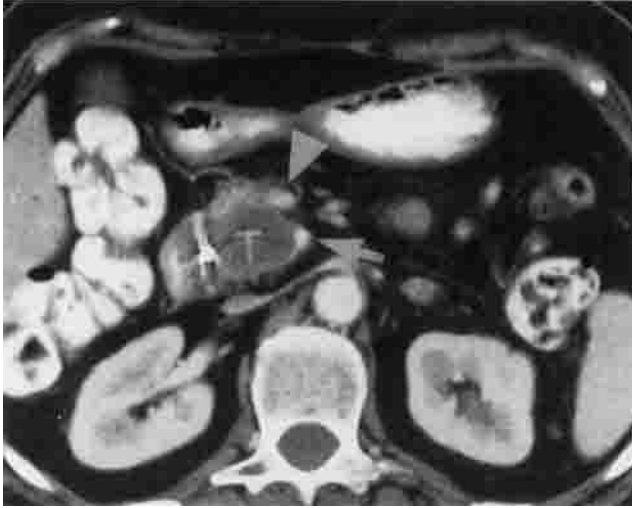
Contrast-enhanced CT scan demonstrating a locally advanced, unresectable adenocarcinoma of the pancreatic head. Note the loss of the normal fat plane between the tumor (T) and both the superior mesenteric vein (arrowhead) and superior mesenteric artery (arrow).
